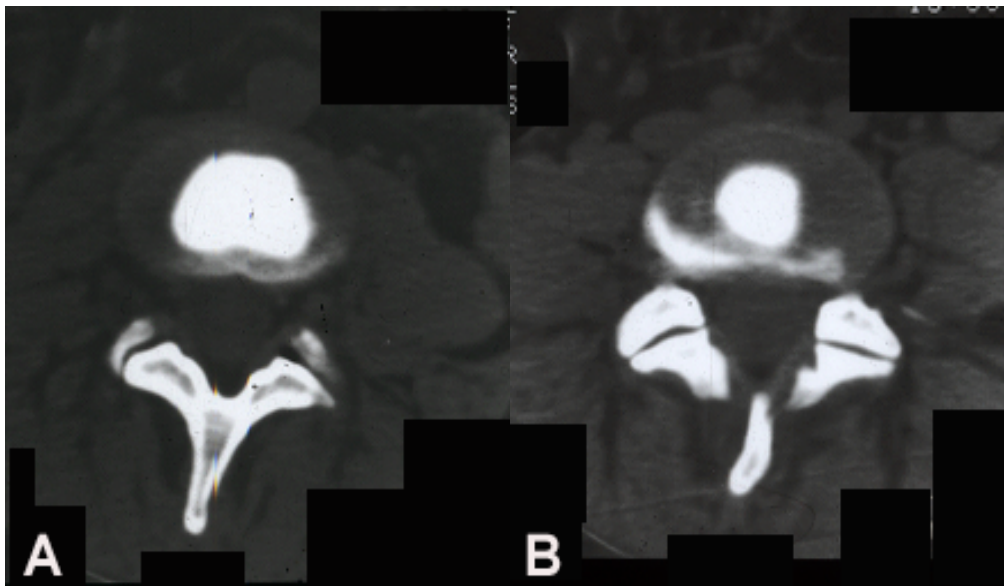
The appearance of discs on CT-discography. A: normal disc. The nucleus is rounded and contained within an intact anulus. B: Internal disc disruption. A radial fissure at 6 o'clock spreads circumferentially around the anulus.
